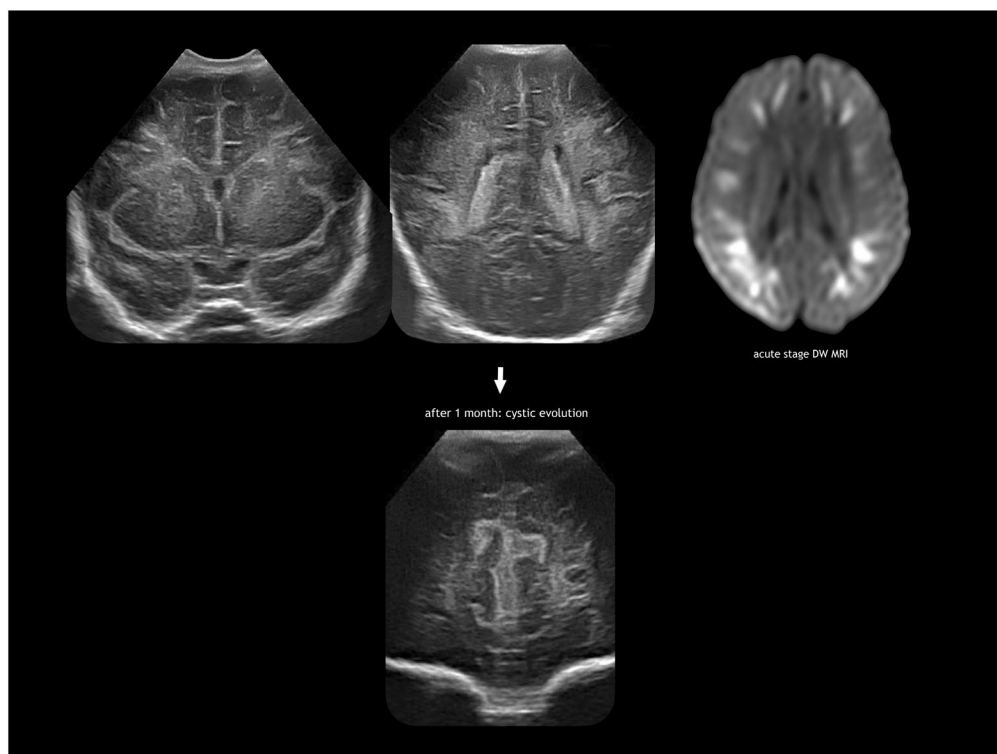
Rotavirus encephalitis-meningitis. Infant born late preterm, seizures caused by rotavirus infection at 2 weeks after birth. Cranial ultrasound imaging showing initial hyperechoic change similar to flaring in preterm white matter injury, but ending in cavitation in the frontal areas (below). Right diffusion-weighted magnetic resonance imaging showing the acute changes. Abbreviation: DW MRI, diffusion-weighted magnetic resonance imaging.
